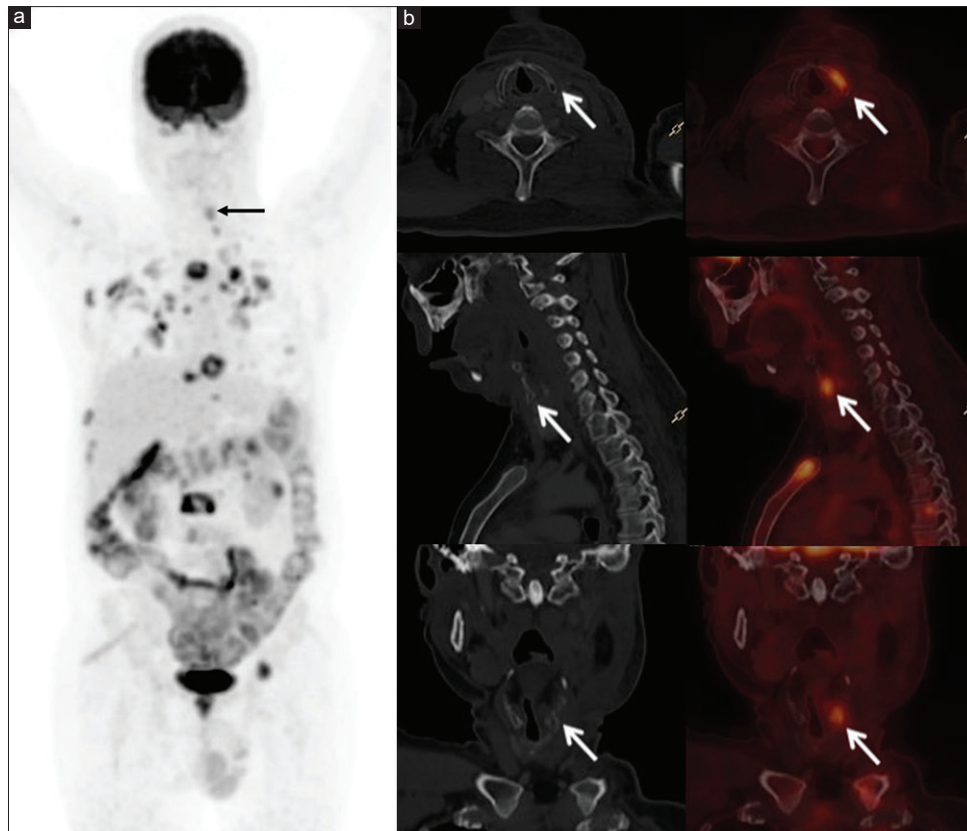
(a) Maximum intensity image of F18-FDG PET, apart from the physiological FDG uptake there is abnormal uptake noted in the neck region (shown by arrow), bilateral lung field, and abdominal region. (b) Erosion of the left lamina of the thyroid cartilage on CT with FDG avidity in corresponding PET/CT in axial, sagittal, and coronal projections, respectively. PET/CT: Positron emission tomography/computed tomography, FDG: Fluorodeoxyglucose
